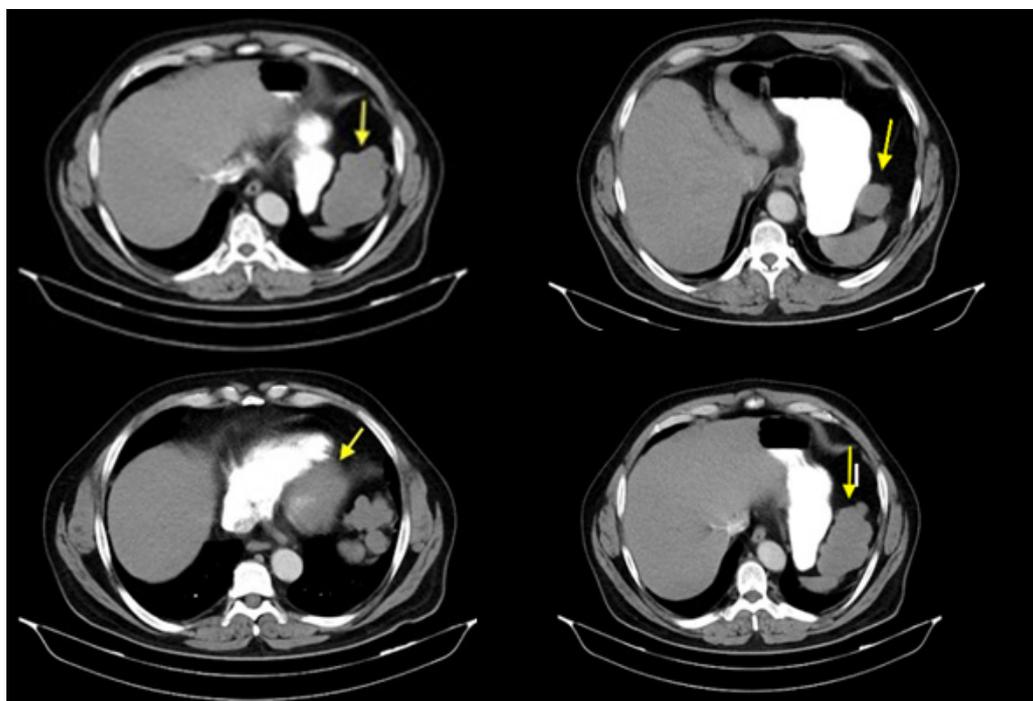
Computed tomography of the abdomen with oral and intravenous contrast.
